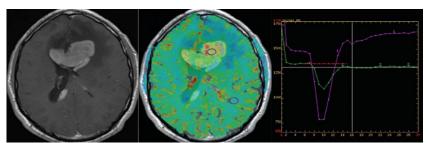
Multimodality cerebral MRI of a middle-aged man with a PCNS lymphoma. T1WI with contrast showing an homogeneous enhancing of two lesions in contact with the ventricles. MRI perfusion of the major lesion shows a weak increase of relative cerebral blood volume, which indicates no significant localized neoangiogenesis (no red area in the lesion). The first pass of the bolus agent curve indicates high blood-brain barrier permeability [1].
